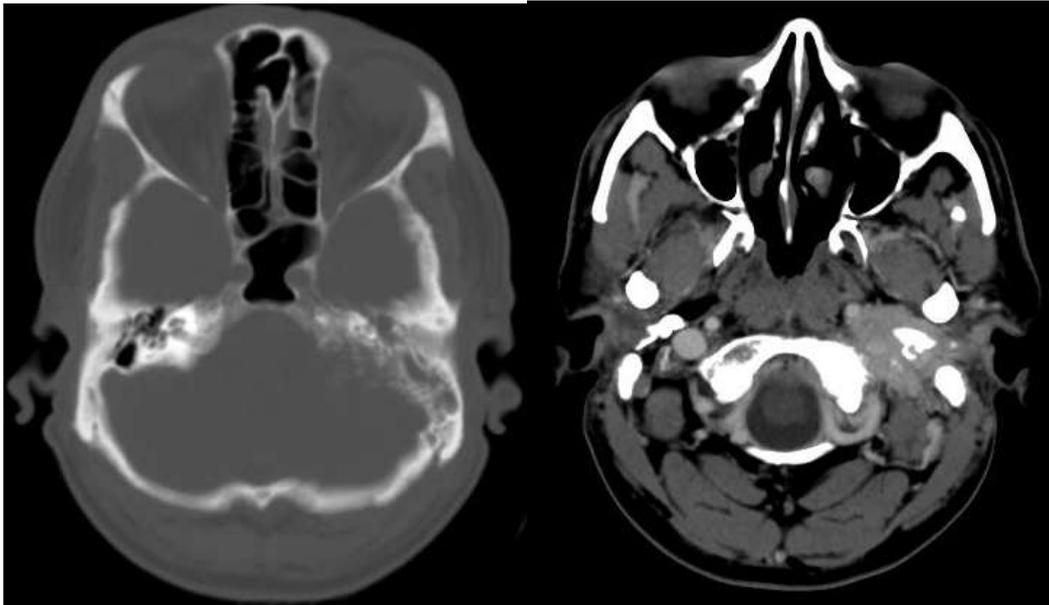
Axial CT scans – Enhancing soft tissue density mass in left jugular fossa with intra-labyrinthine, intracranial (CP angle) extension and erosion of left petrous ridge.
